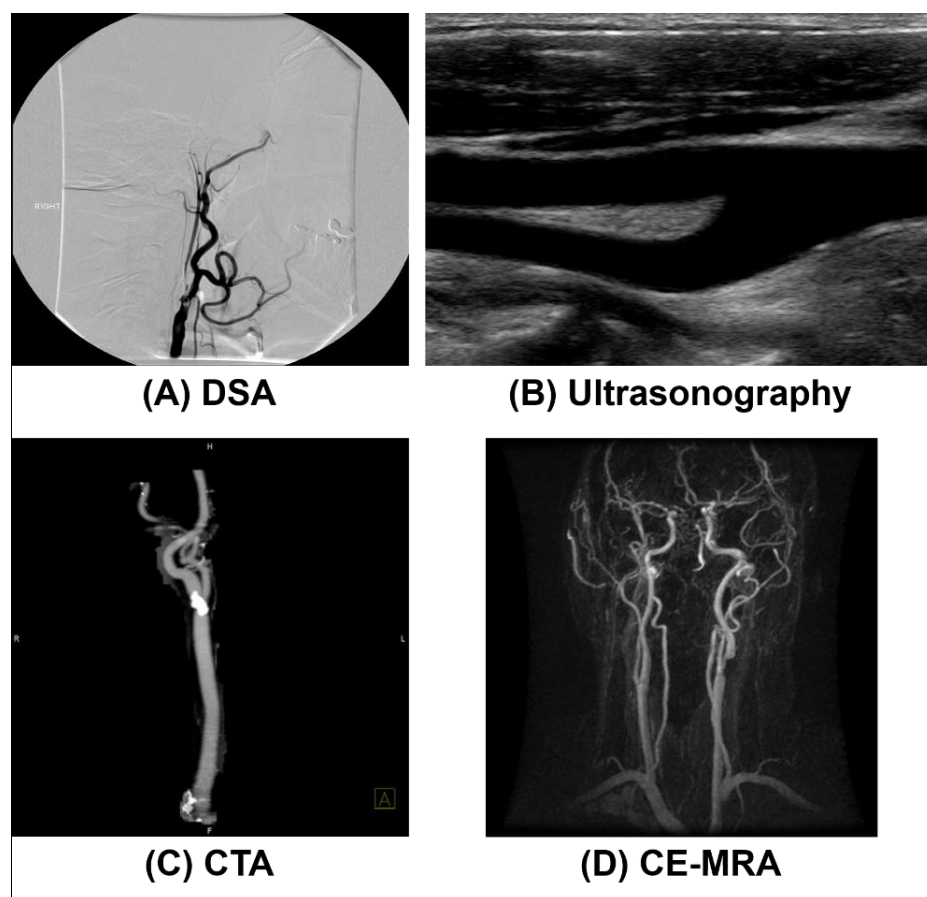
Typical images of carotid arteries obtained by (A) DSA, (B) ultrasonography, (C) CTA and (D) CE-MRA. Images courtesy of Martin J Graves.
